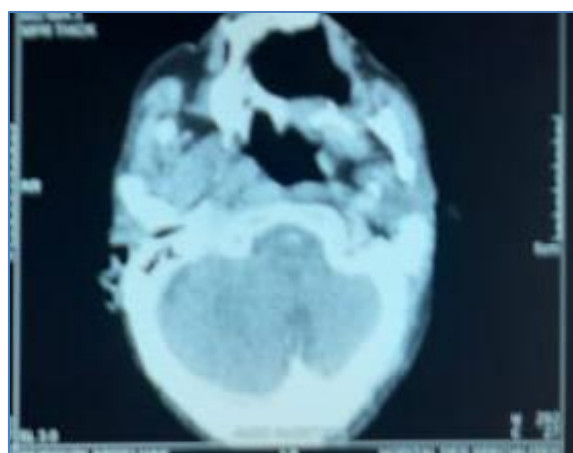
Facial CT in axial section after injection of the contrast product showing an irregular thickening of the cavum with effacement of the rosen-muller fossa
